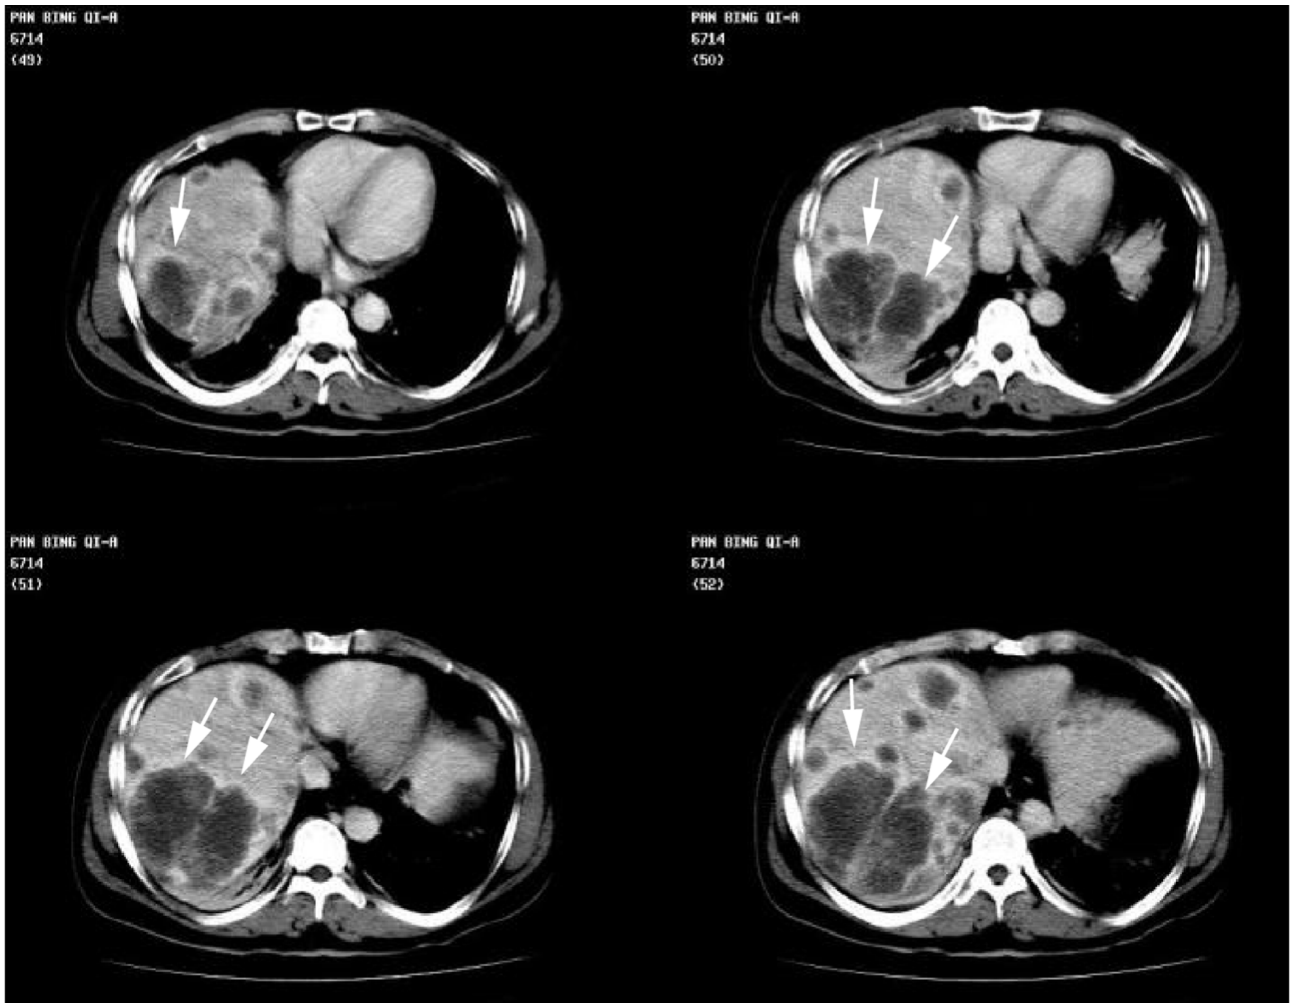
Imaging findings of plain and enhanced CT in HCC patients. This patient had persistent pain in the right upper quadrant, with progressive aggravation and emaciation for more than one month. The CT scan showed multiple intrahepatic low-density lesions with varying size and irregular shape, which were considered liver cancer with multiple intrahepatic metastases. After enhancement, the lesions showed significant annular enhancement, while the middle low-density lesions showed no apparent enhancement, which was considered as necrotic tissue. Arrows show the liver cancer.
